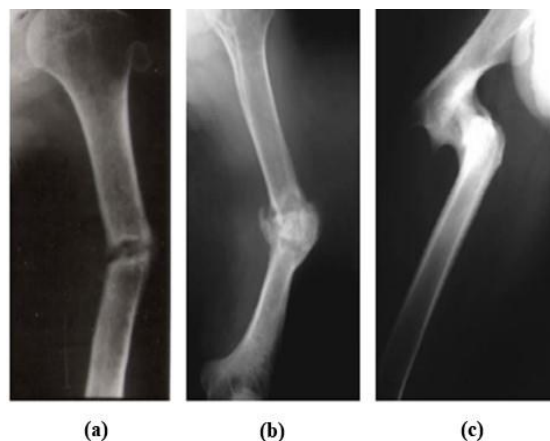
Radiographic images of a delayed union, non-union and mal-union. (a) Humeral delayed union, (b) atrophic non-union of the midshaft of the humerus, (c) severe mal-union of the proximal femur; the fracture united with shortening of 5 cm and severe malalignment due to complete translation and angulation. Adapted from [59], [60].
